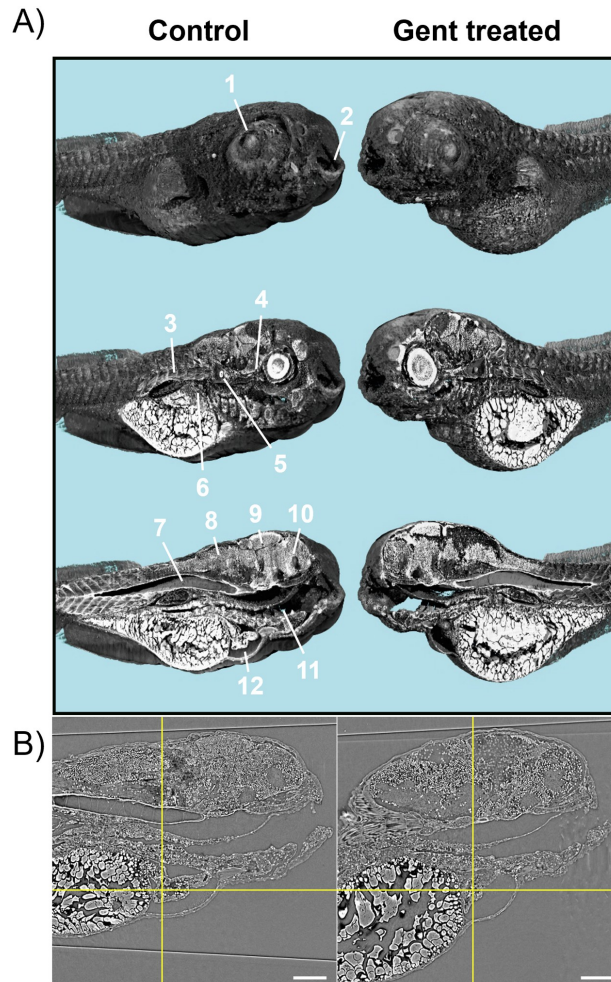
Synchrotron radiation-based computed tomography (SR μ CT) of control and gentamicin-treated ZFL. (A) 3D renderings of 96 hpf ZFL at 24 hpi of 1 nL of control buffer (left panels) or 1 nL of 42 mM gentamicin (right panels) with sagittal cuts. Pixel size: 0.65 μ m. Anatomical structures: 1 = eye lens, 2 = mouth, 3 = muscle tissues, 4 = optical nerve, 5 = otoliths, 6 = liver, 7 = notochord, 8 = hindbrain, 9 = midbrain, 10 = frontbrain, 11 = intestine, 12 = heart. (B) Representative virtual slices through the heart chambers (yellow reticle) of control (left) and 1 nL of 42 mM gentamicin (right) treated ZFL. Scale bar: 100 μ m.
